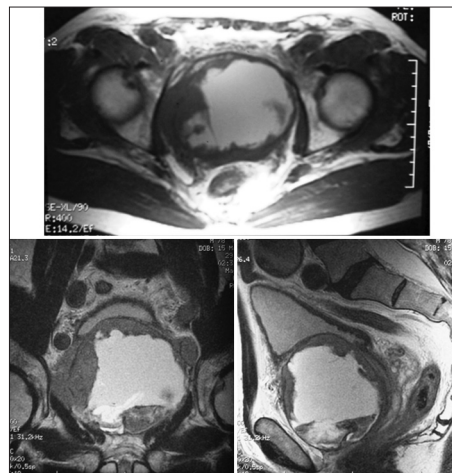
MRI at diagnosis confirmed numerous cysts within a markedly enlarged prostate (333 cc) with atypical T1 and T2 signals
